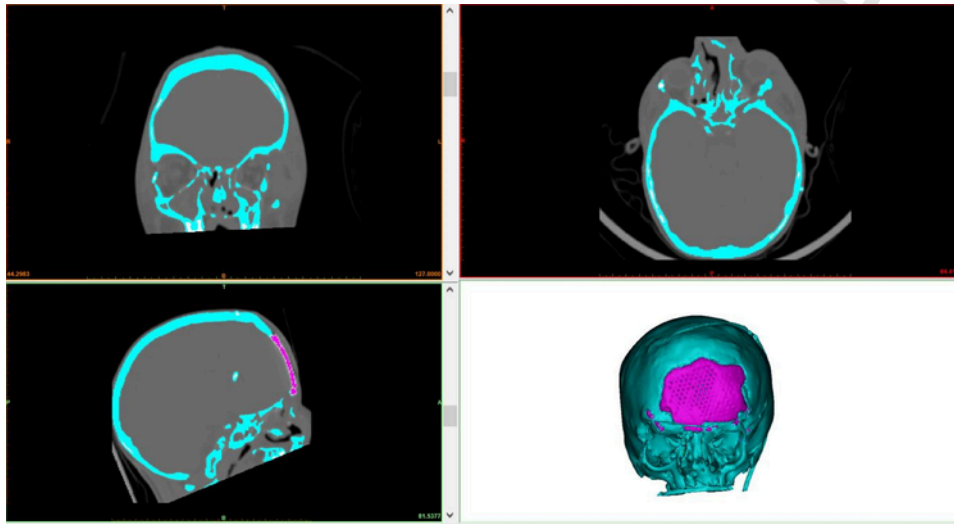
CT scan of the patient with corrected defect. In pink the new cranial plate; in cyan the segmented bone after surgery. (For interpretation of the references to colour in this figure legend, the reader is referred to the web version of this article.)
